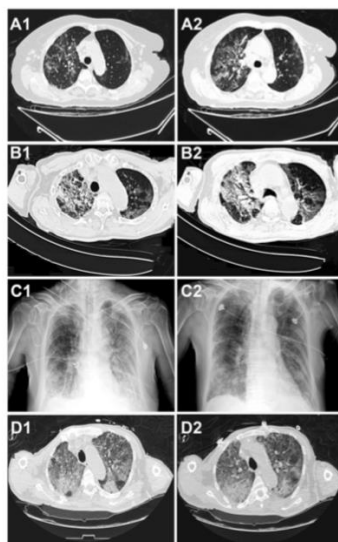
Radiographic image of chest CT scan and X-ray of COVID-19 patients. Left and right images show earlier and latter time points, respectively [5].
